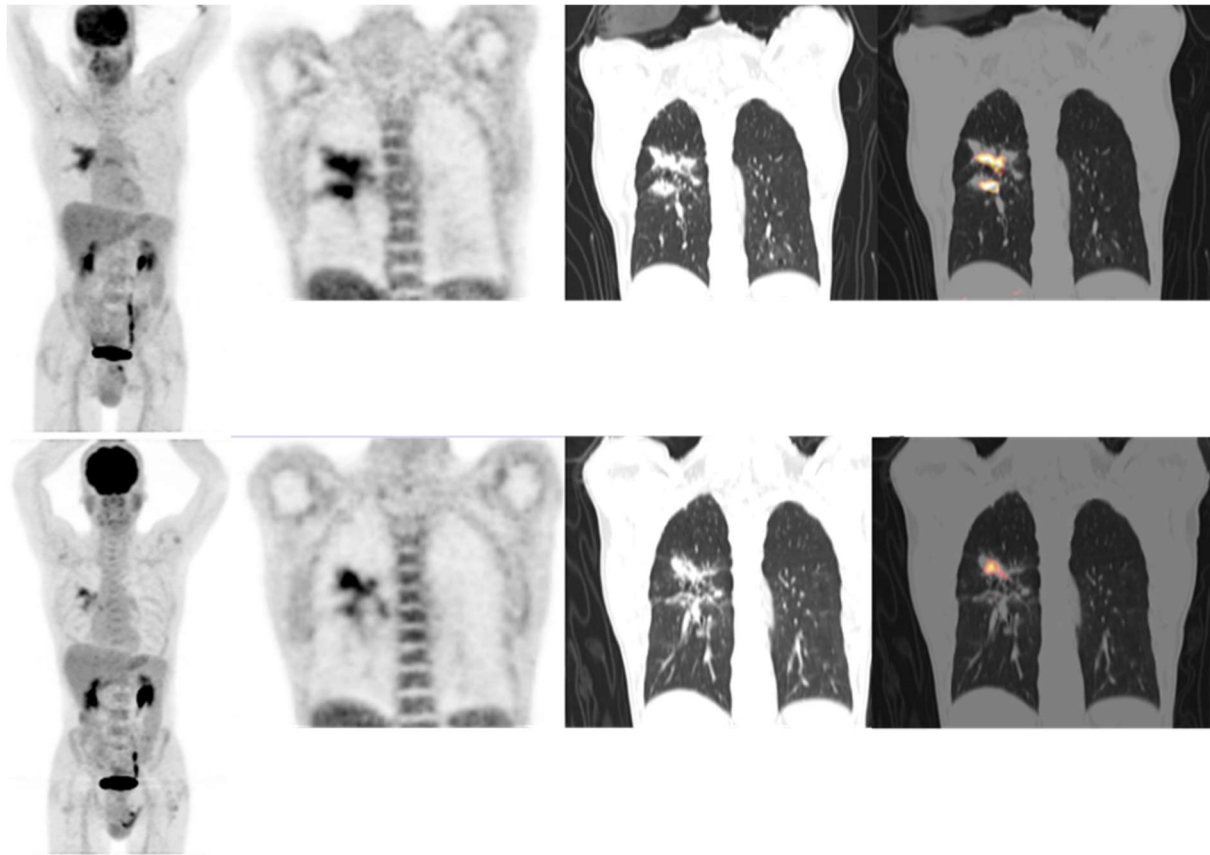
A 65-year-old male who completed a standard 6-month course of anti-tuberculous treatment. He was symptom-free and was gaining weight at the end of treatment. His sputum was negative for *Mycobacterium tuberculosis* growth. He was declared cured of tuberculosis based on these. An end-of treatment FDG PET/CT (top row) show two foci of increased FDG uptake in the right lung consistent with residual metabolic activity. Five months later, his respiratory symptoms recurred, and his sputum was positive for *Mycobacterium tuberculosis*, consistent with relapse of tuberculosis. Repeat FDG PET/CT (bottom row) show the persistence of the of the foci of increased FDG uptake in the right lung and an almost complete resolution of the other. No new lesion is seen. These findings suggest the presence of persisting bacilli at the end of treatment despite negative culture result.
